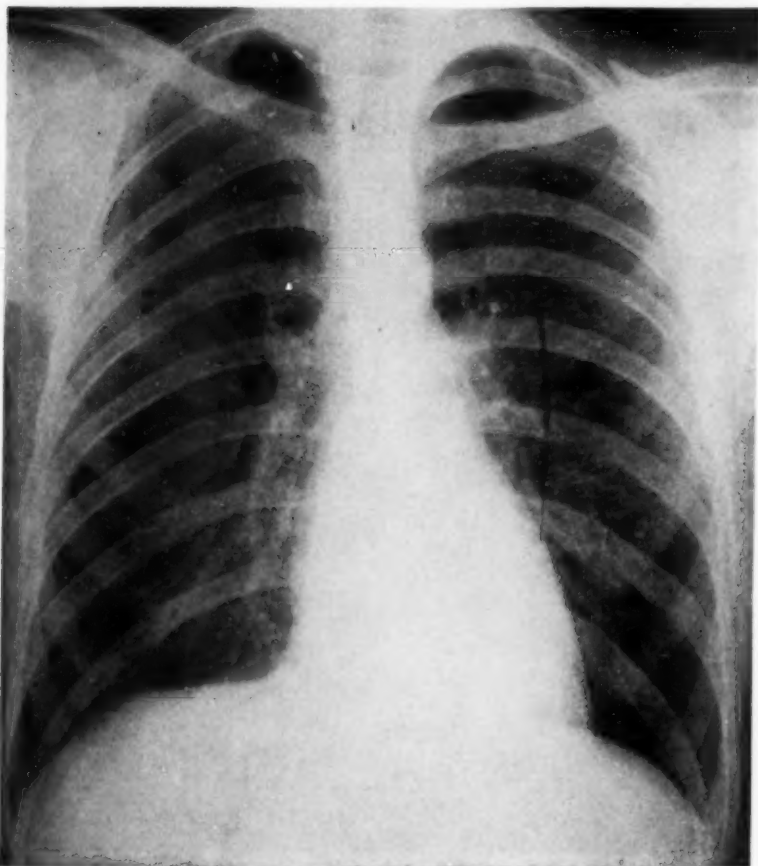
Chest x-ray of another patient prior to onset of pericarditis.
